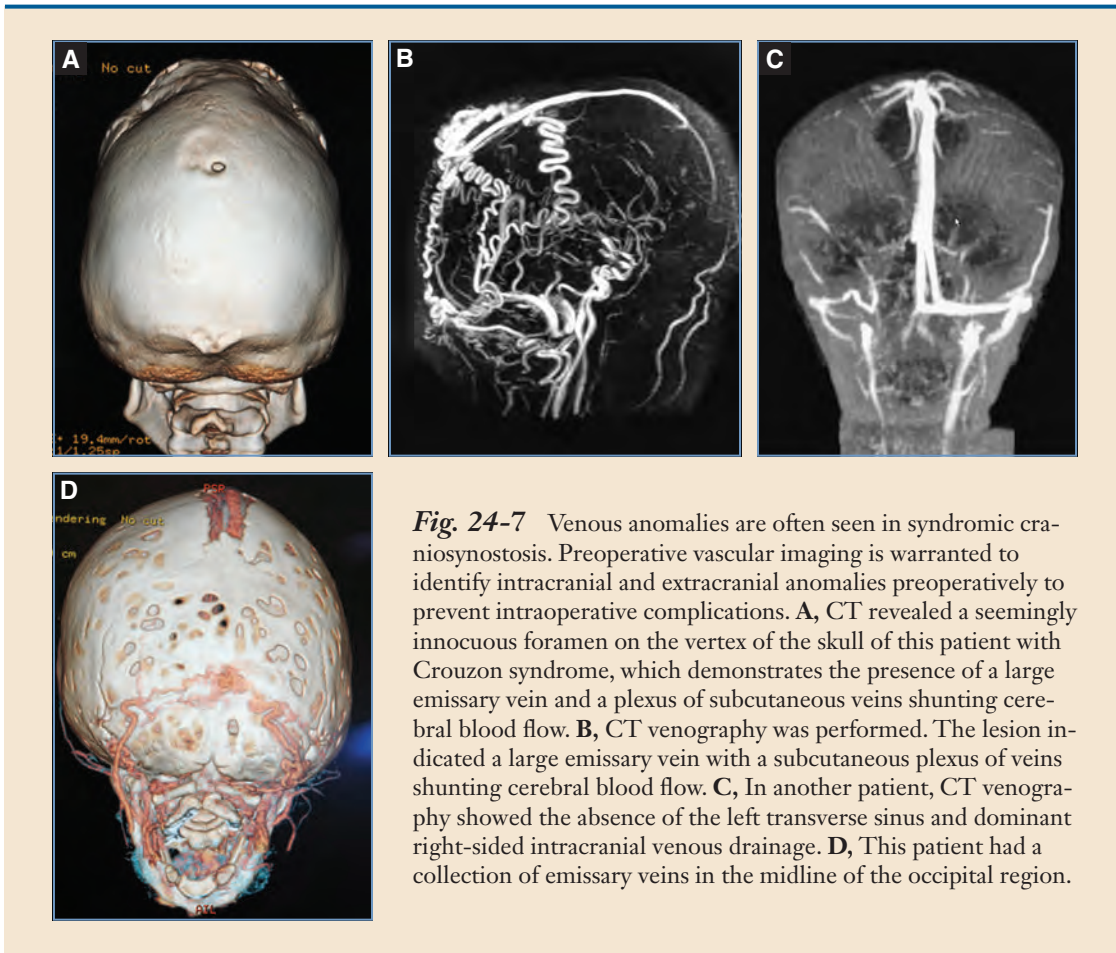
Venous anomalies are often seen in syndromic craniosynostosis. Preoperative vascular imaging is warranted to identify intracranial and extracranial anomalies preoperatively to prevent intraoperative complications. A, CT revealed a seemingly innocuous foramen on the vertex of the skull of this patient with Crouzon syndrome, which demonstrates the presence of a large emissary vein and a plexus of subcutaneous veins shunting cerebral blood flow. B, CT venography was performed. The lesion indicated a large emissary vein with a subcutaneous plexus of veins shunting cerebral blood flow. C, In another patient, CT venography showed the absence of the left transverse sinus and dominant right-sided intracranial venous drainage. D, This patient had a collection of emissary veins in the midline of the occipital region.
